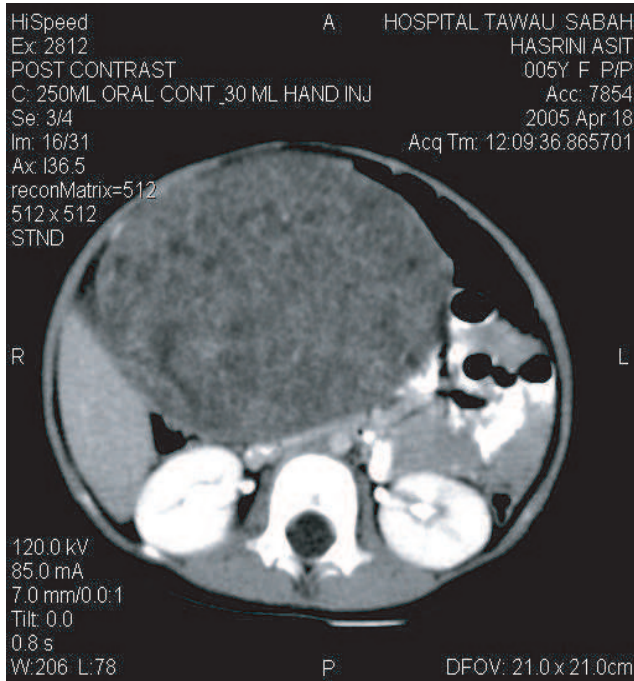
CT scan showing the ovarian teratoma
